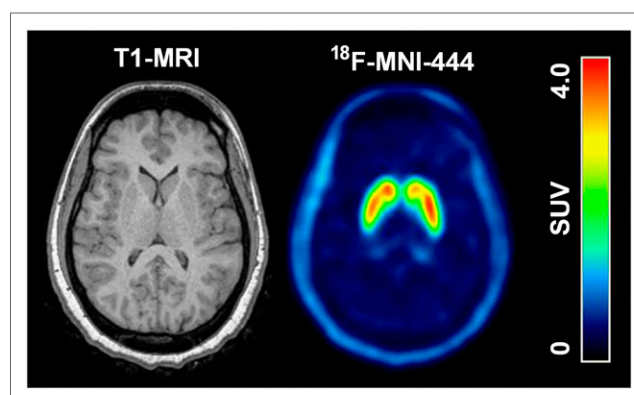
Representative transverse PET sum image (30–90 min) of ^{18}F -MNI-444 distribution in human brain with correspondent T1 MR image.
